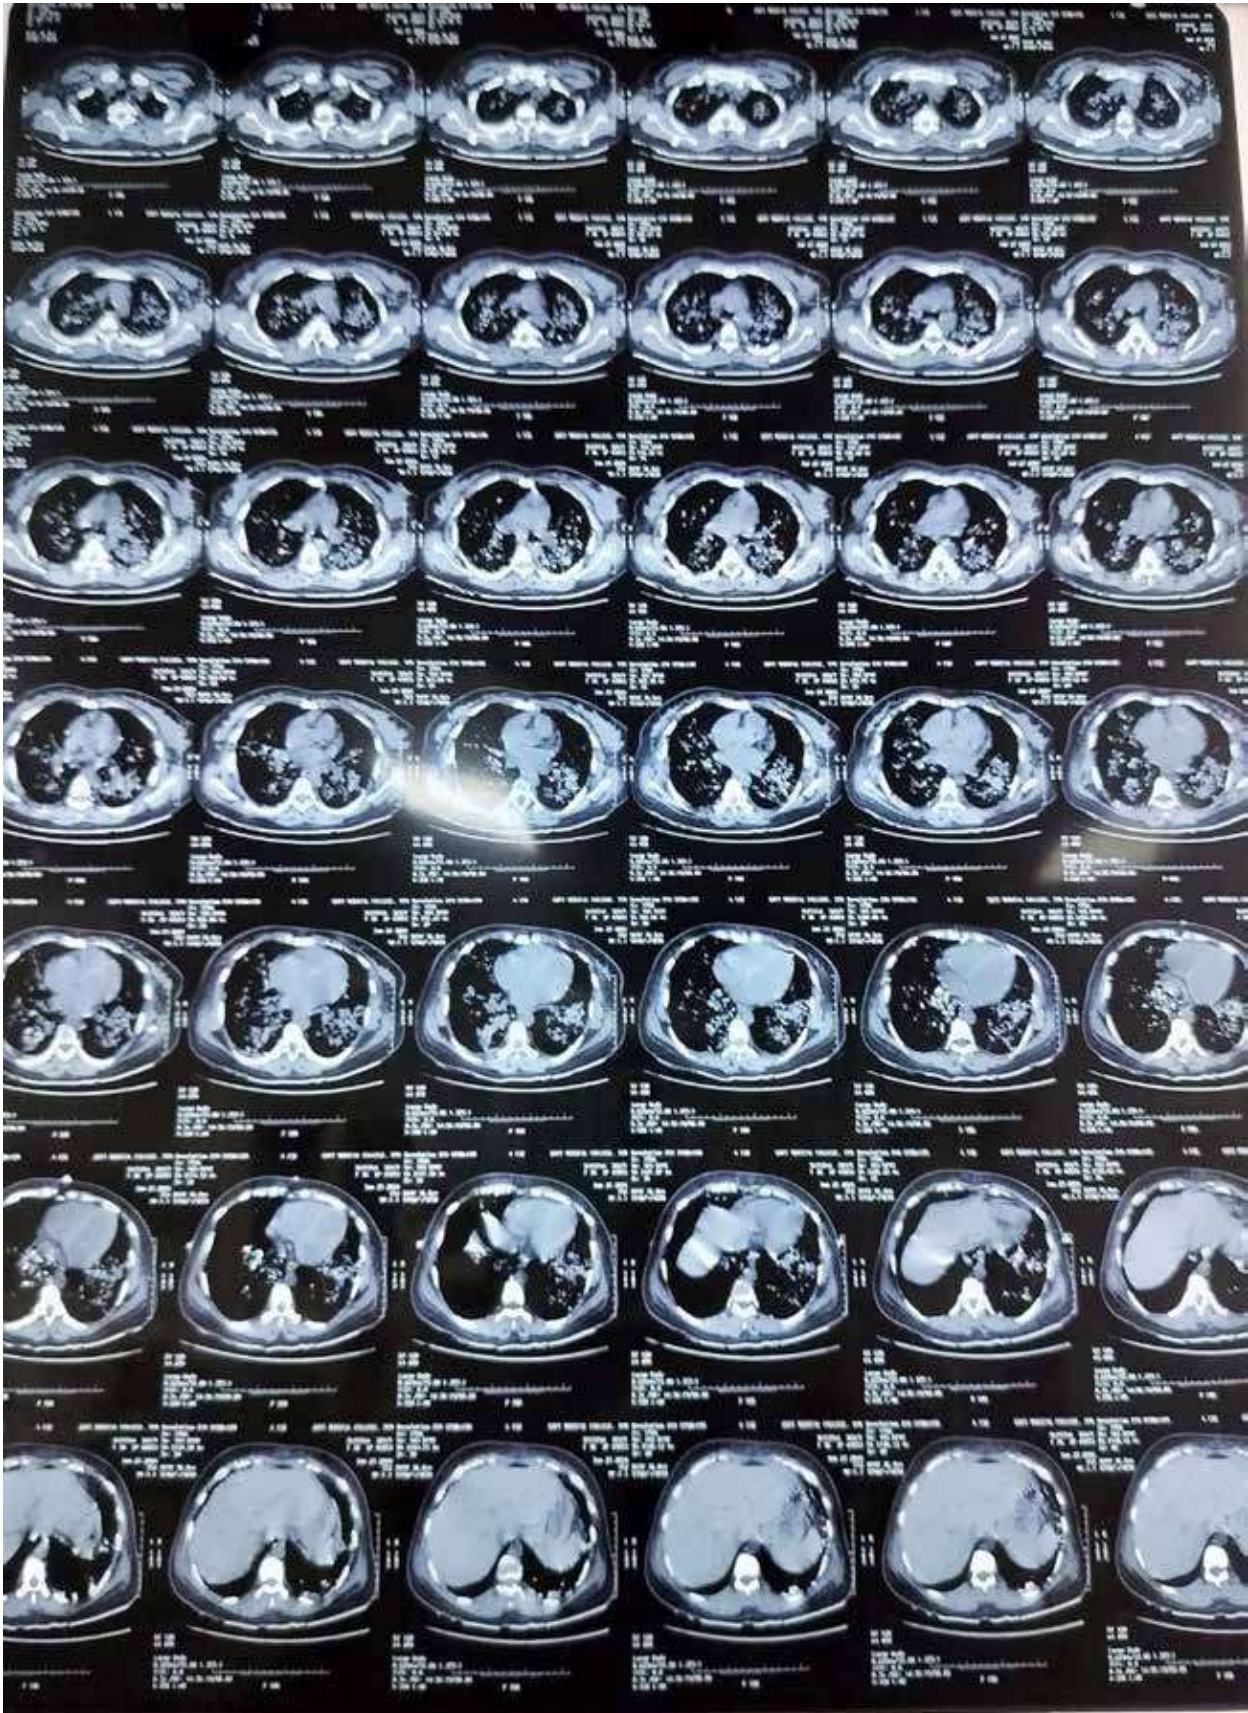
CT Chest demonstrating peribronchovascular consolidation with ground-glass opacities across all lobes
